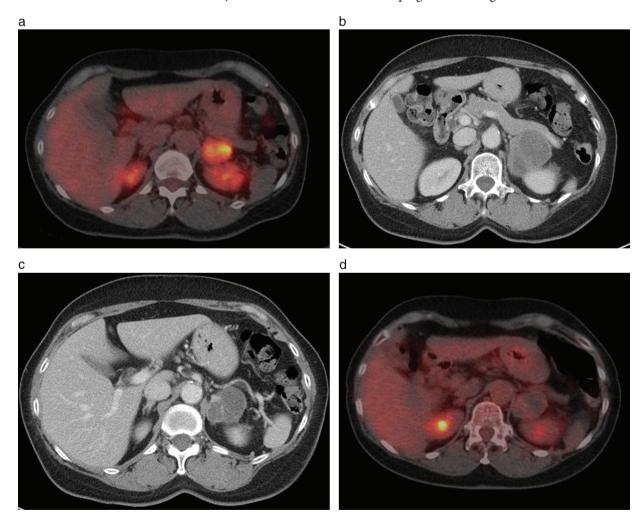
Case 1. (a) Positron emission tomography-computed tomography (PET-CT) showed accumulation of fluorodeoxyglucose (FDG) on the left adrenal gland. (b) After two cycles of chemotherapy, consisting of carboplatin (AUC 5, day 1), paclitaxel (500 mg/m², day 1) and bevacizumab (15 mg/kg, day 1), left adrenal gland metastasis progressed. (c) CT images revealed a partial response after 11 cycles of nivolumab treatment: the adrenal grand had reduced in size. (d) Accumulation of FDG on the left adrenal gland disappeared after 15 cycles of nivolumab treatment.
